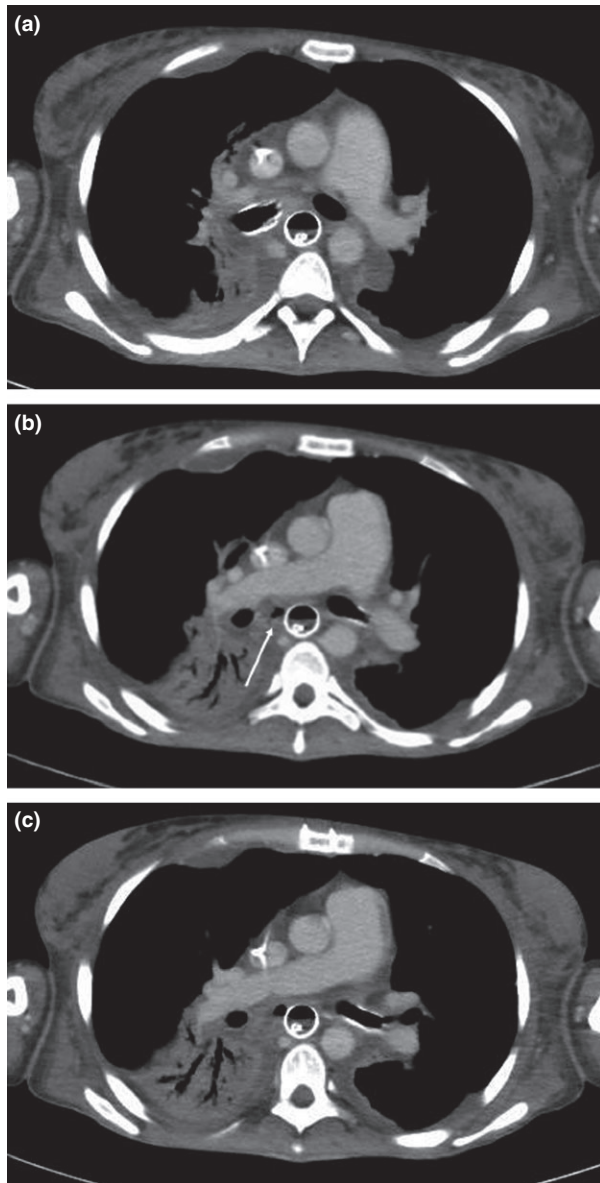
Contrast-enhanced CT showing: (a, c) the right and left bronchial stents, respectively, the esophageal stent and the nasogastric tube inside the esophageal stent; (b) air in the fistulous tract (arrow), excluded by the stents.
